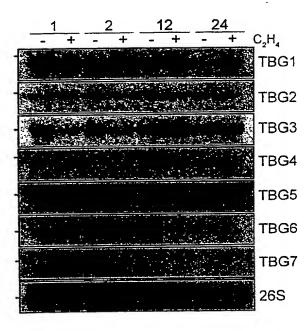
Autoradiograph of northern blot analysis of TBG expression in response to ethylene treatment of mature green fruit tissues. Twenty μg of total RNA extracted from peel and outer pericarp tissue at various times (1, 2, 12 and 24 hours) after treatment with (+) or without (-) 10 ppm ethylene was loaded in each lane. RNAs were separated in an agarose gel and transferred to nylon membrane. Blots were hybridized using the probes indicated to the right, washed to a final stringency of 0.1X SSC at 65°C and were used to expose x-ray film. A 26S ribosomal gene clone from soybean was used as a loading control for each blot and one example is shown. The - marks on the left indicate the position of the tomato 27S rRNA.
